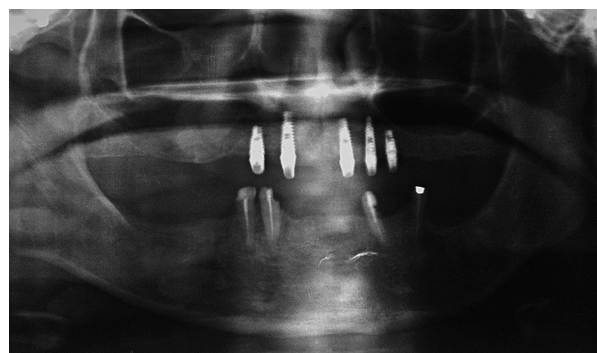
Postoperative 4 months DPT radiograph.
